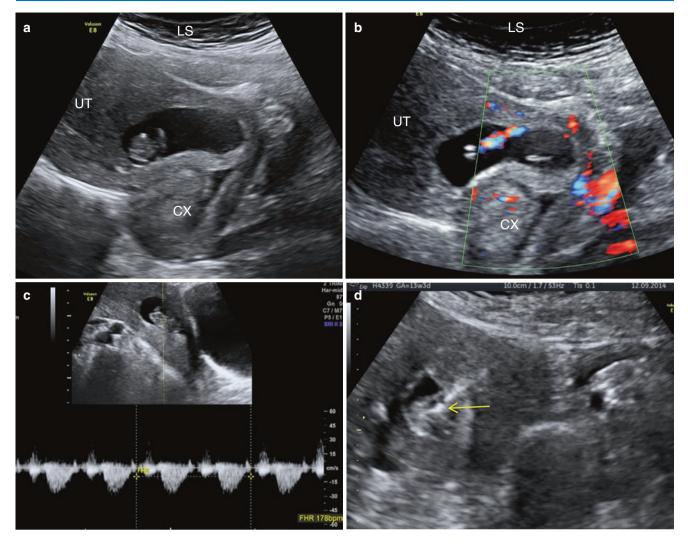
Live scar ectopic pregnancy with a 10-week-old fetus. (a) The GS and trophoblastic tissue is seen bulging out of the anterior wall of the uterus at the site of the LSCS scar. (b) Flow is seen around the trophoblastic tissue and in the umbilical cord on Doppler. (c) Tracing of fetal heart pulsations. (d) Fetal reduction done with KCl. *Arrow* showing the needle
